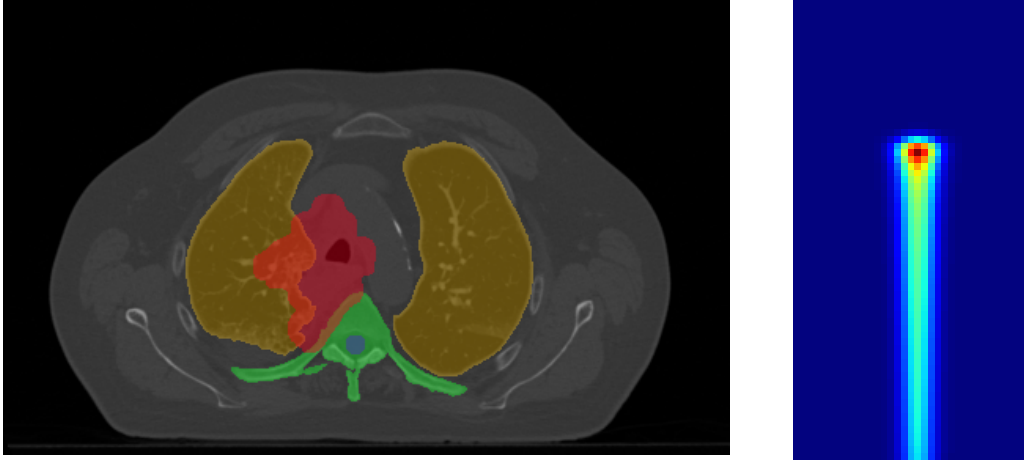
Example of visual outputs: a CT slice with several binary masks of different body structures (left) and the dose distribution of a single proton pencil beam (right).
